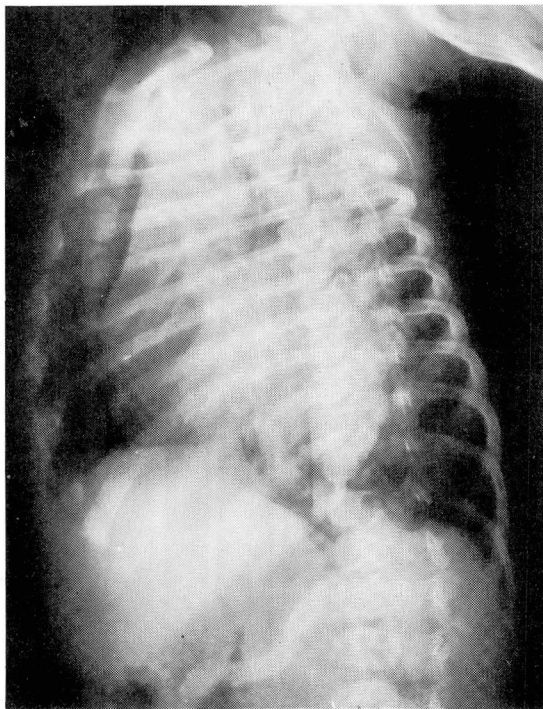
Case 1. Oblique roentgenogram of the chest, demonstrating herniation of right middle lobe in the anterior mediastinum.
